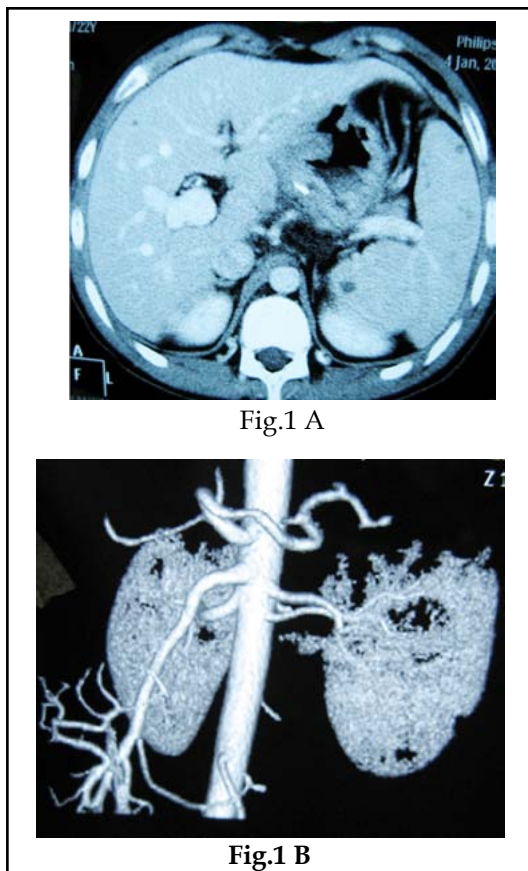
(A) The computed tomography (CT) scan suggested no recurrence of tumor.
